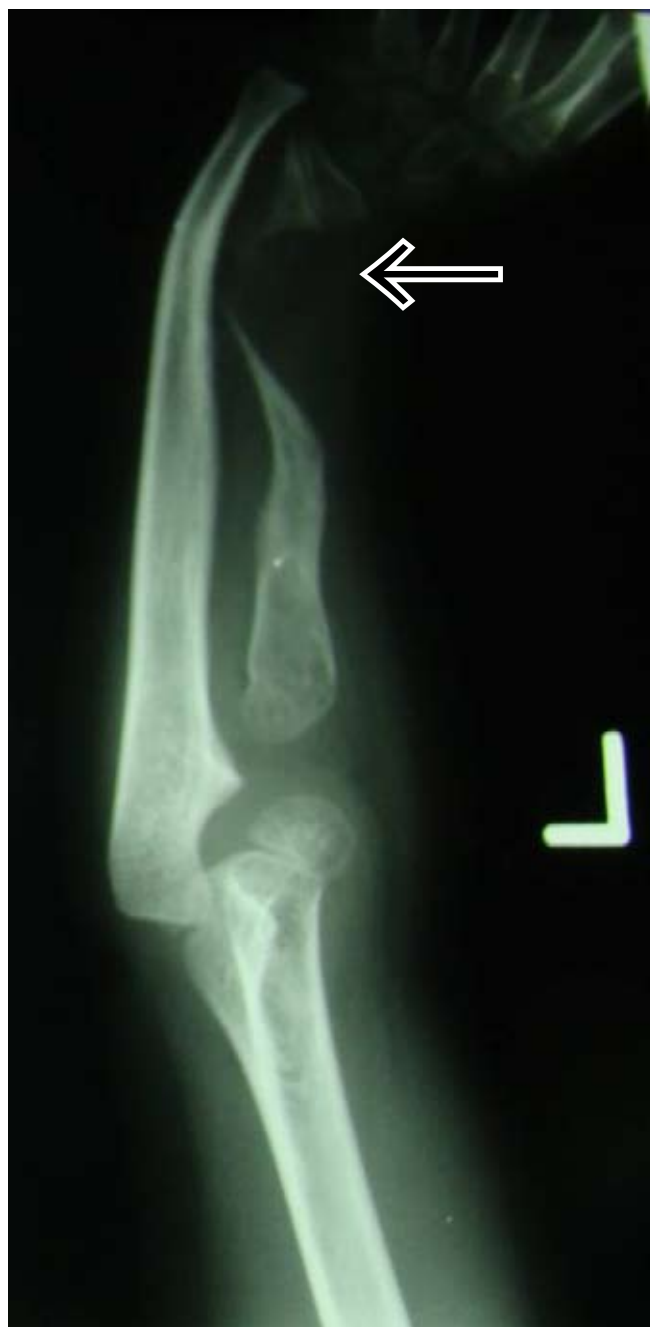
Anteroposterior X-ray of the forearm with thinned atrophic distal radius.
